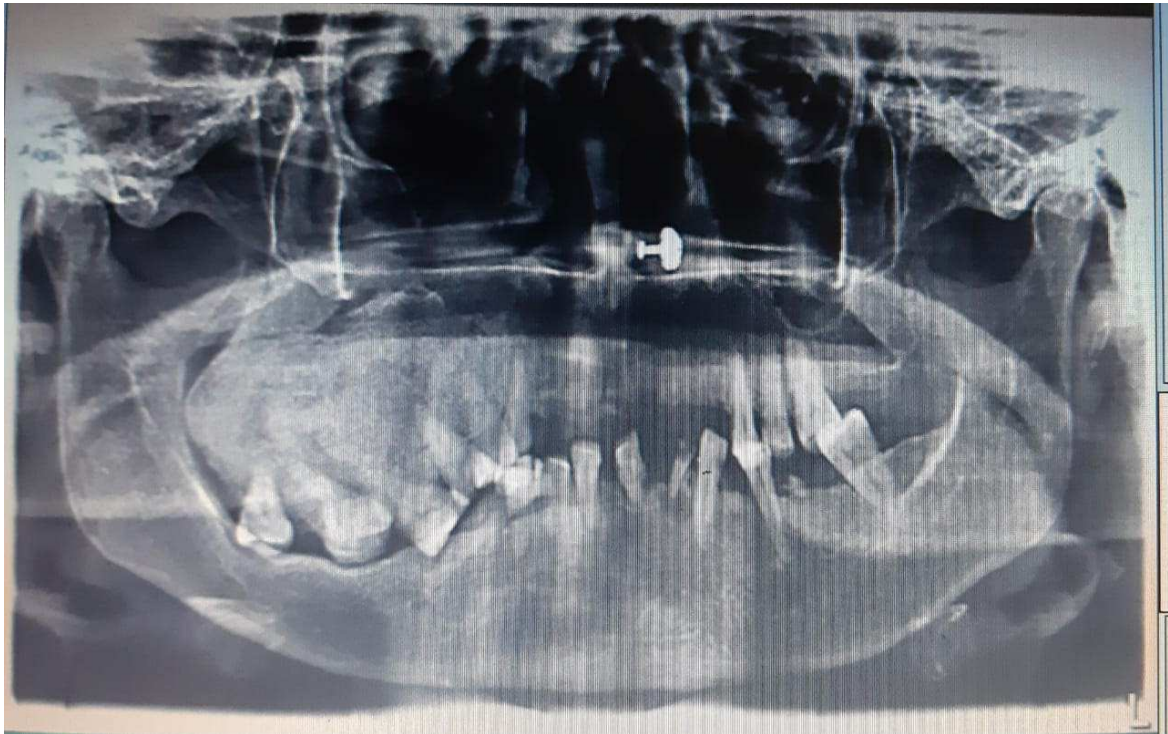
An orthopantomogram showing well defined radiopaque lesion on the right maxilla posterior segment causing extreme deformity of right maxilla and mobility of left maxillary posteriors.
